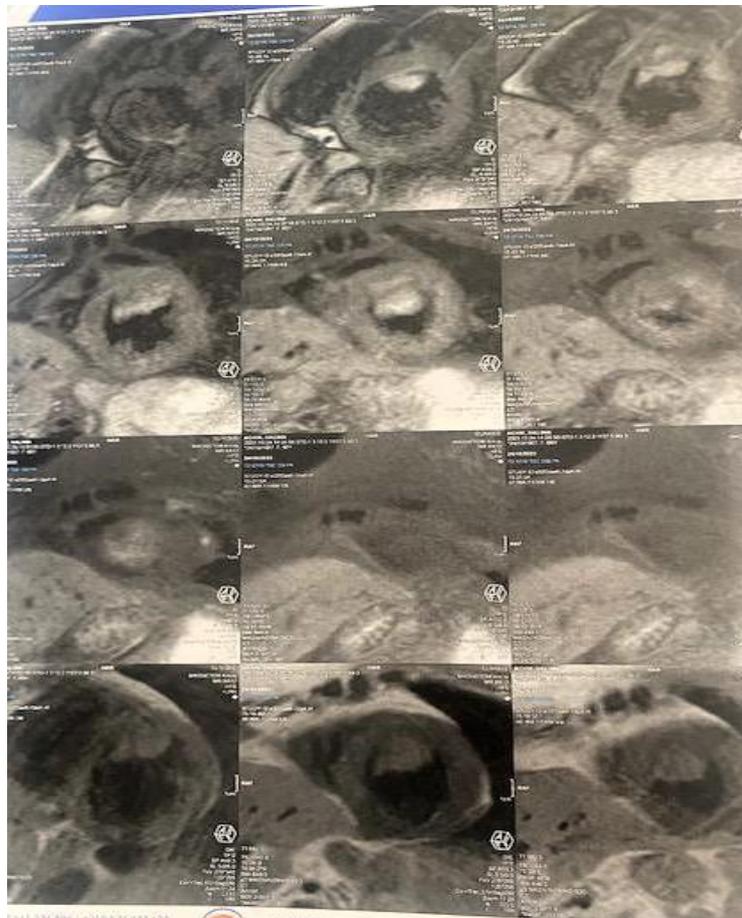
MRI cardiac thrombosis
